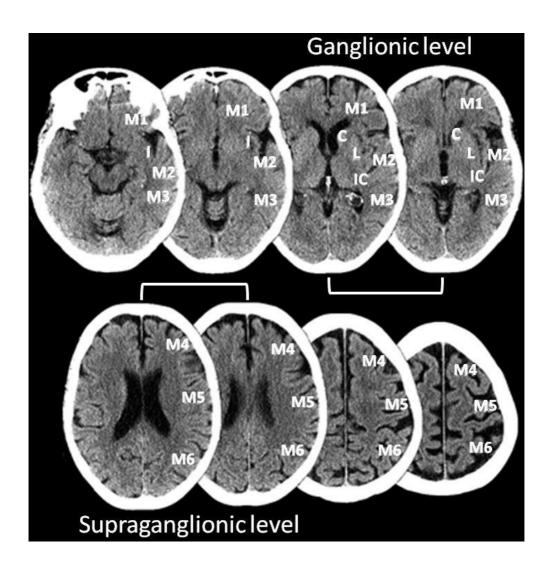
Axial NECT images showing the MCA territory subregions as defined by ASPECTS. White brackets indicate the ganglionic and supraganglionic levels. C - Caudate nucleus, I - Insular ribbon, IC - Internal capsule, L - Lentiform nucleus, M1 - Anterior MCA cortex, M2 - MCA cortex lateral to the insular ribbon, M3 - Posterior MCA cortex, M4, M5, and M6 - the anterior, lateral and posterior MCA territories immediately superior to M1, M2 and M3, respectively, and rostral to the basal ganglia. Subcortical structures are allotted 3 points and the MCA cortex is allotted 7 points. The image is adapted from www.aspectsinstroke.com
